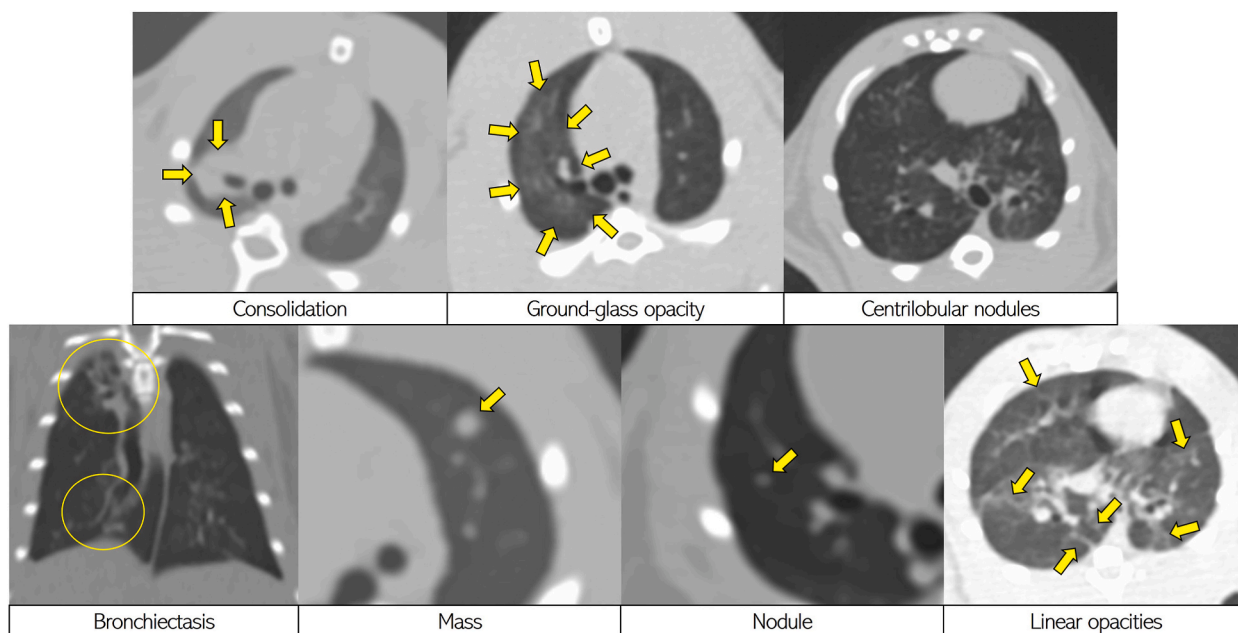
Characteristic CT findings.
